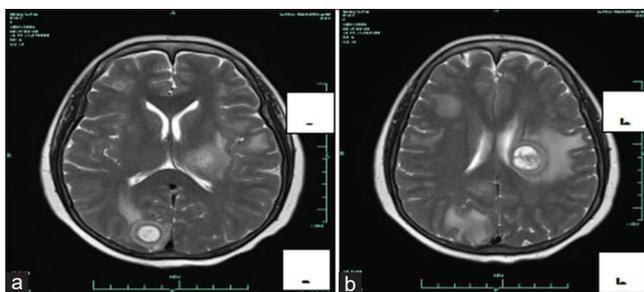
Cranial magnetic resonance imaging revealing multiple calcification metastases with edema (a and b)
